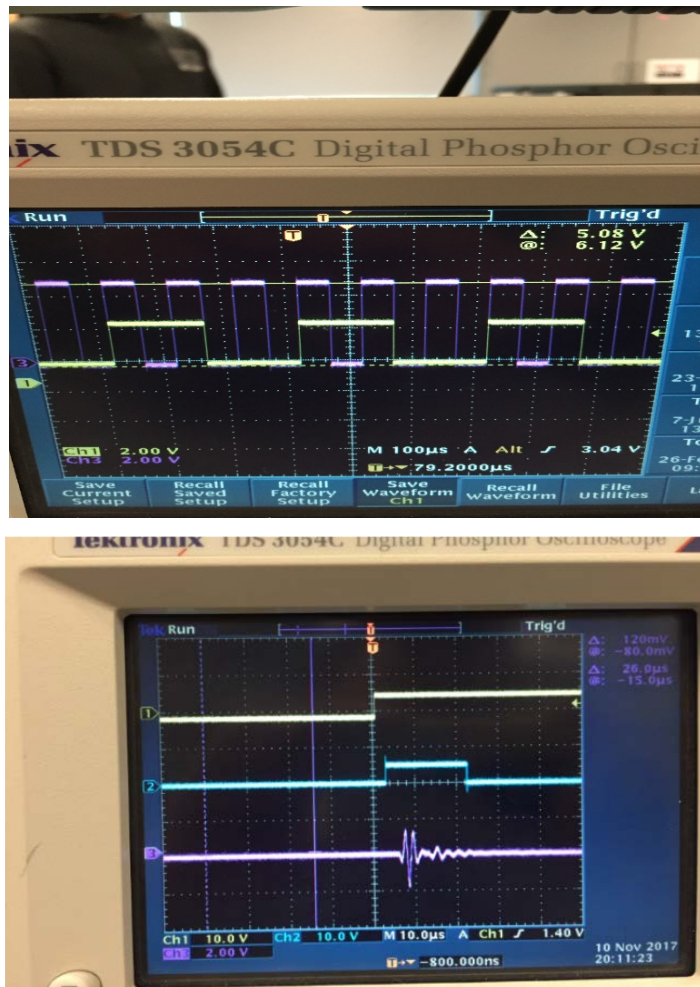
Top image shows the OCT Computer Output Signal (Purple trace) and the virtualbench output signal (Yellow trace). In this configuration the parameters in the formula above were set to $f_{in} = 10\text{kHz}$, $DC_i = 50\%$, $RE_{on} = 2$, $RE_{off} = 2$. As shown in the figure the virtualbench output is on for 2 OCT Computer Output Signal rising edges and off for 2 OCT rising edges. Bottom image shows OCT trigger (Yellow trace), Ultrasound stimulation signal (Blue trace), and Ultrasound receiver waveform (Purple trace).
